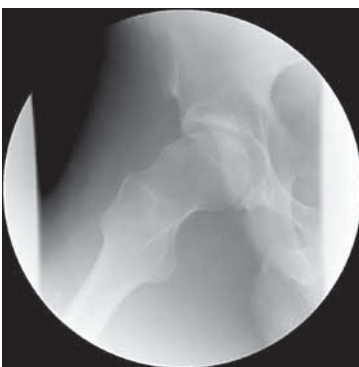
An example of cam impingement of the hip on X-ray using the Lauenstein technique: there is an extra “bump” (pistol-grip formation) of the proximal femoral neck leading to impingement against the acetabulum when the hip is flexed and internally rotated.
